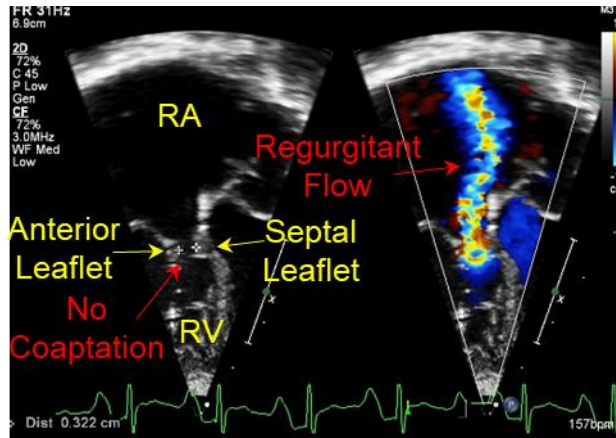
2DTTE (*left*) and color Doppler imaging (*right*) of the four-chamber view of an infant patient with pulmonary atresia. Image courtesy of Children’s Heart Center at the OU Health Sciences Center.
